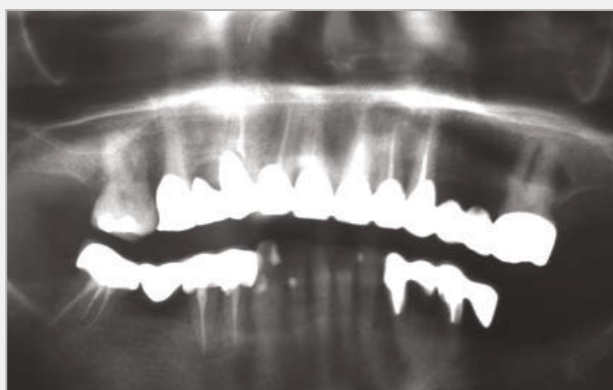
Case 3 - Panoramic x-ray with the initial status.
